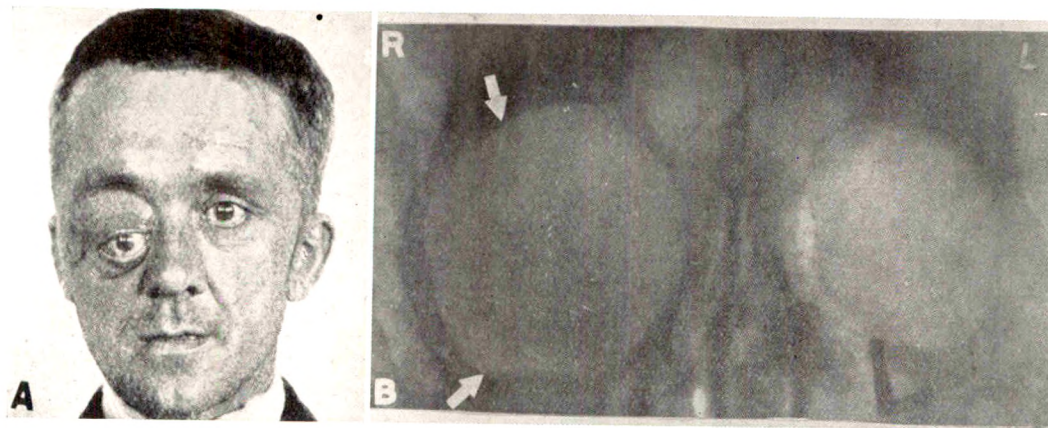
Moore's case. A. Pulsating exophthalmos, right eye. Ligation of carotid artery, but pulsating and protrusion continued, neurofibromatosis also present. B. Roentgenogram shows deficiency of posterior orbital wall and larger orbital cavity on the right side. This case might easily have been mistaken for sarcoma.
